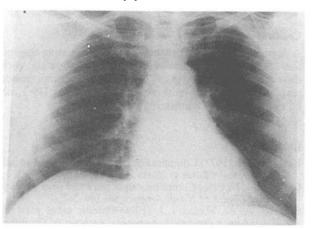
Pre-operative X-ray chest, PA view.
